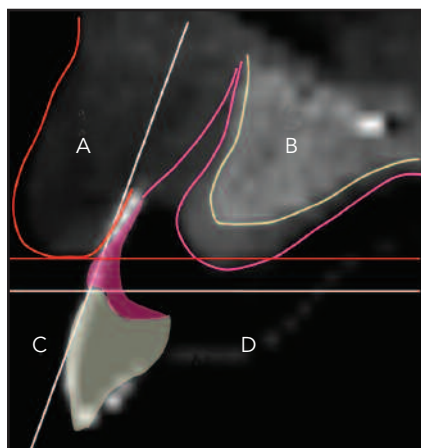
Two virtual lines drawn on the CT create four quadrants: the lip zone (A), the hard and soft tissue and implant-surgical zone (B), the visible esthetic zone (C), and the restorative zone (D). The ideal position of the buccal surface of the crown and gingival margin will generate the vertical line. The cemento-enamel junction of the central incisor will establish the horizontal line. The red line corresponds to the lip line when smiling. In the first step of restoring this patient, the bone and soft tissue graft should be planned to bring the ridge forward toward the vertical line, filling in the B quadrant but not invading A.
